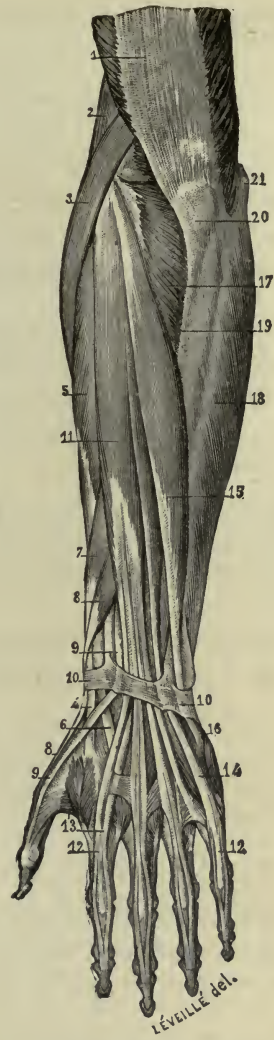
MUSCLES OF THE FOREARM, DORSAL ASPECT.
